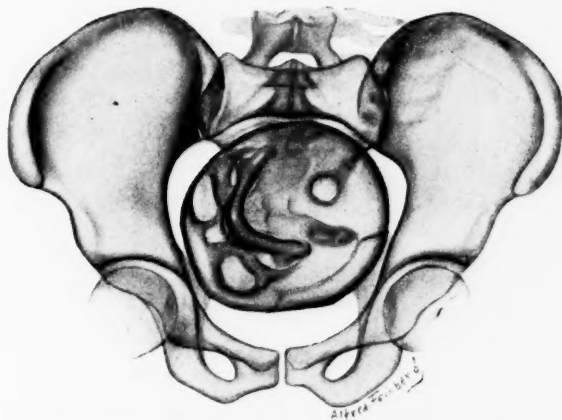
First x-ray examination early in labor shows vertex L. O. P. situated over posterior pelvis. Type of pelvis android with anthropoid characteristics.
